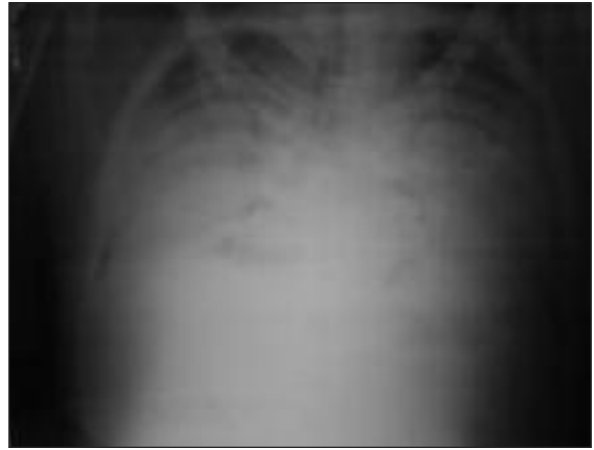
Chest X-ray of case 1.
